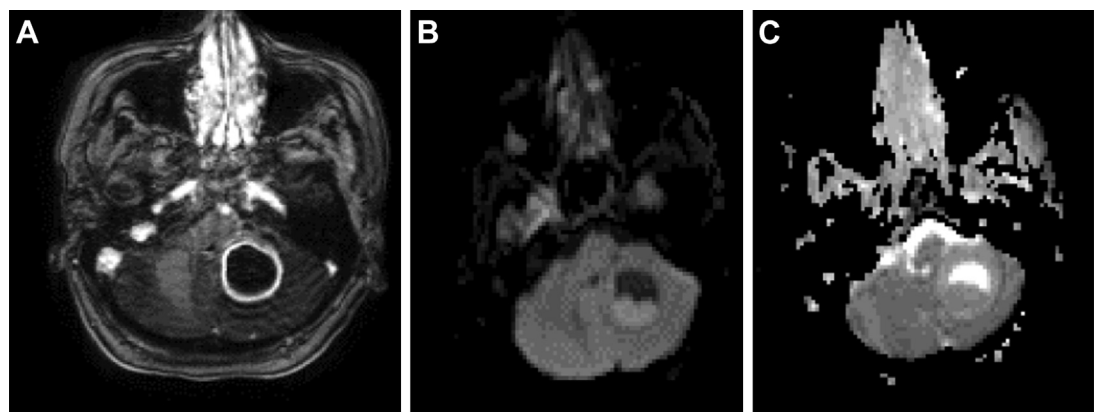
Tuberculous abscess. A large, solitary abscess shows thin rim enhancement on axial T1-weighted postcontrast MR imaging (A) with central diffusion restriction on DWI (B, C).
